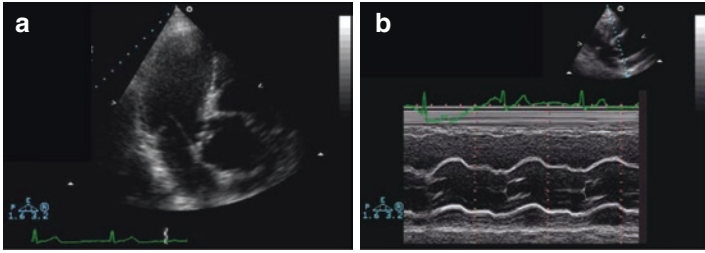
Echocardiogram at the first visit (Panel a: 5 chamber; panel b: M-mode long axis)
